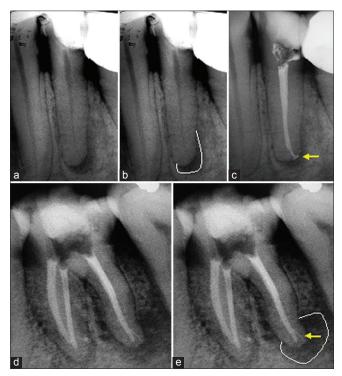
Eccentric location of the periapical radiolucency (deviation from the long axis of the root) is a landmark for either (a-c) a lateral opening of the main foramen (yellow arrow), or (d and e) the presence of lateral canals (yellow arrow)
